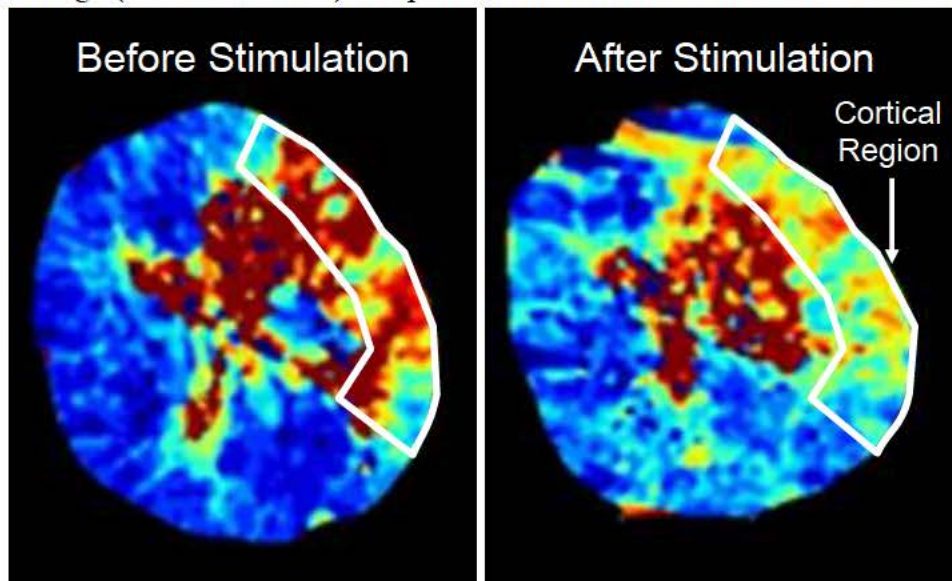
CT Perfusion of a CCI Patient Before and After SPG Stimulation
